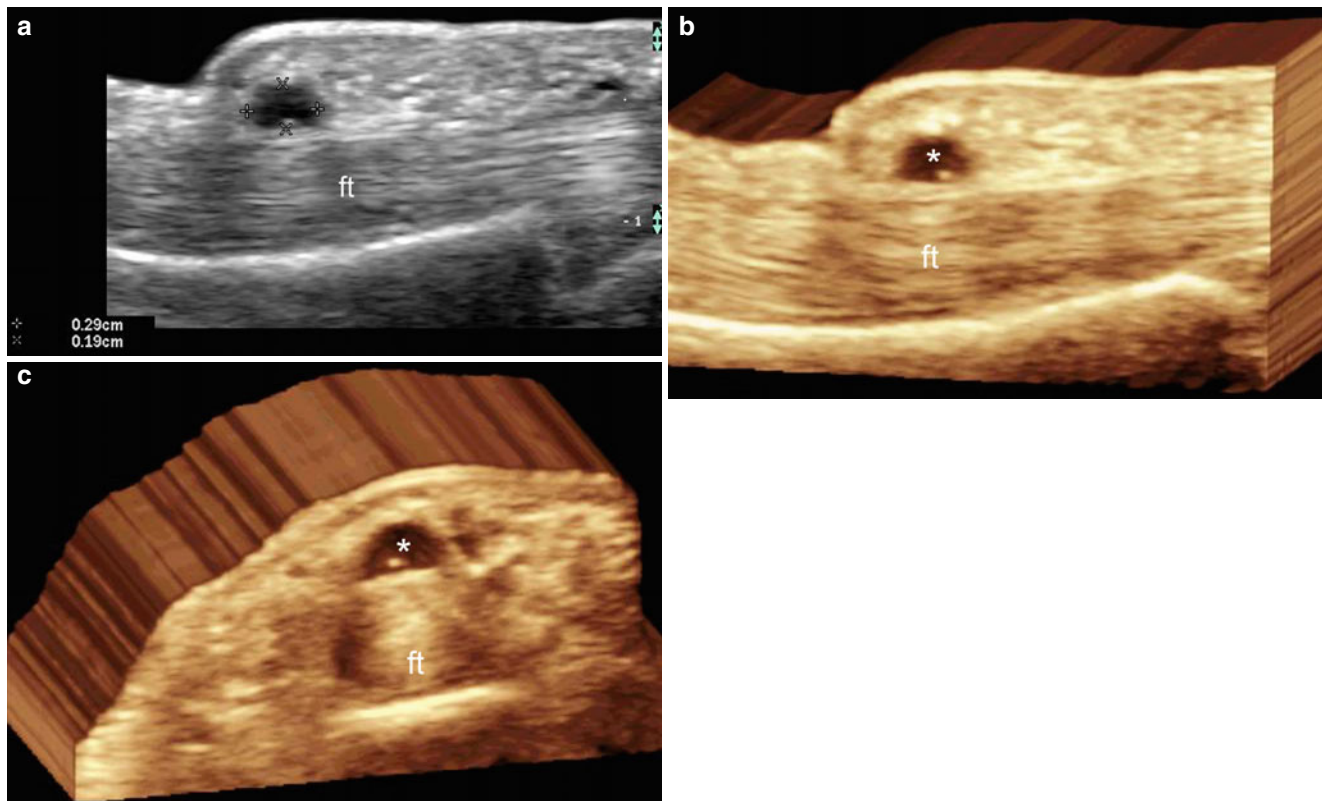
(a–c) Synovial cyst. (a) Grey scale ultrasound image (longitudinal view; left middle finger) shows a 2.9 mm (long) × 1.9 mm (deep) well-defined round-shaped anechoic cystic structure attached to
